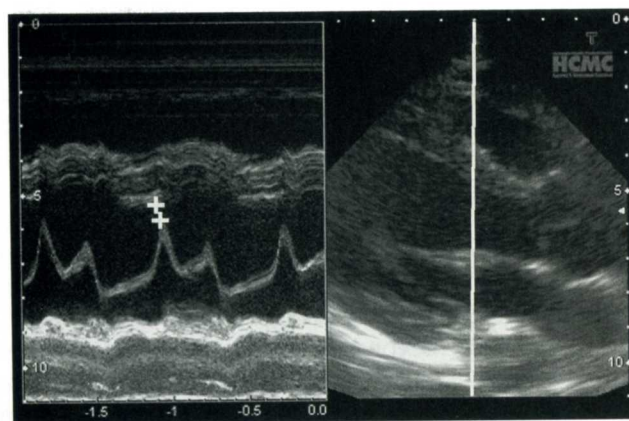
Split screen M-Mode ultrasound at mitral valve level. White line indicates approximate position of M-Mode cursor for recording anterior mitral valve leaflet. Measurement cursors are positioned for EPSS which equals 6 mm in this example. (Courtesy of Hennepin County Medical Center)
